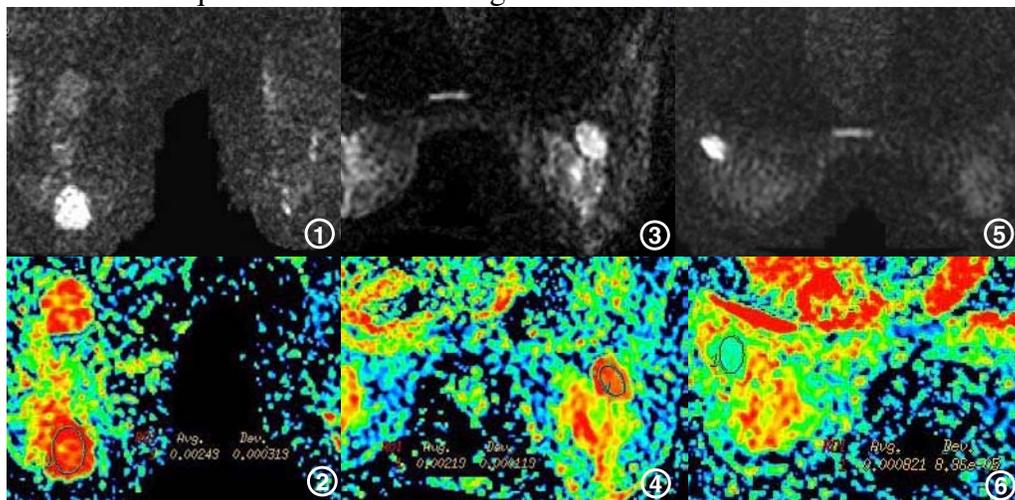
80 years old female patient with mucinous adenocarcinoma. The tumor showed hyperintensity on DWI (Fig1) and high ADC value on ADC rainbow map (Fig2). Fig3, 4. 42 years old female patient with right breast fibroadenomatosis. The lesion displayed hyperintensity on DWI (Fig3) and high ADC value (Fig4). Fig5. 51 years old female patient with invasive ductal carcinoma. The tumor showed low ADC value on ADC map.
